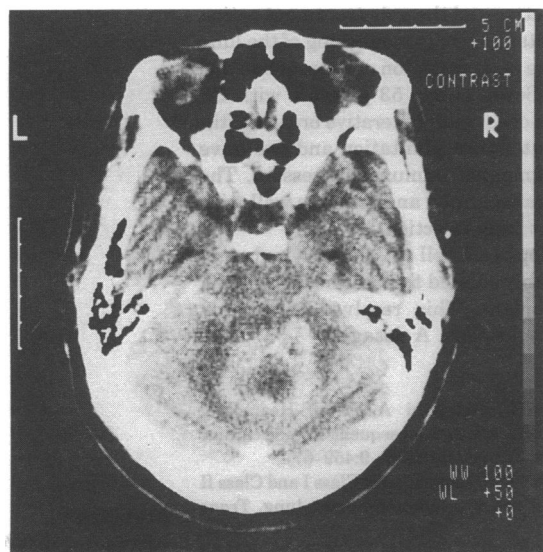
CT-scan examination at admission showing contrast-enhancing lesion in the cerebellar vermis and right cerebellar hemisphere.
